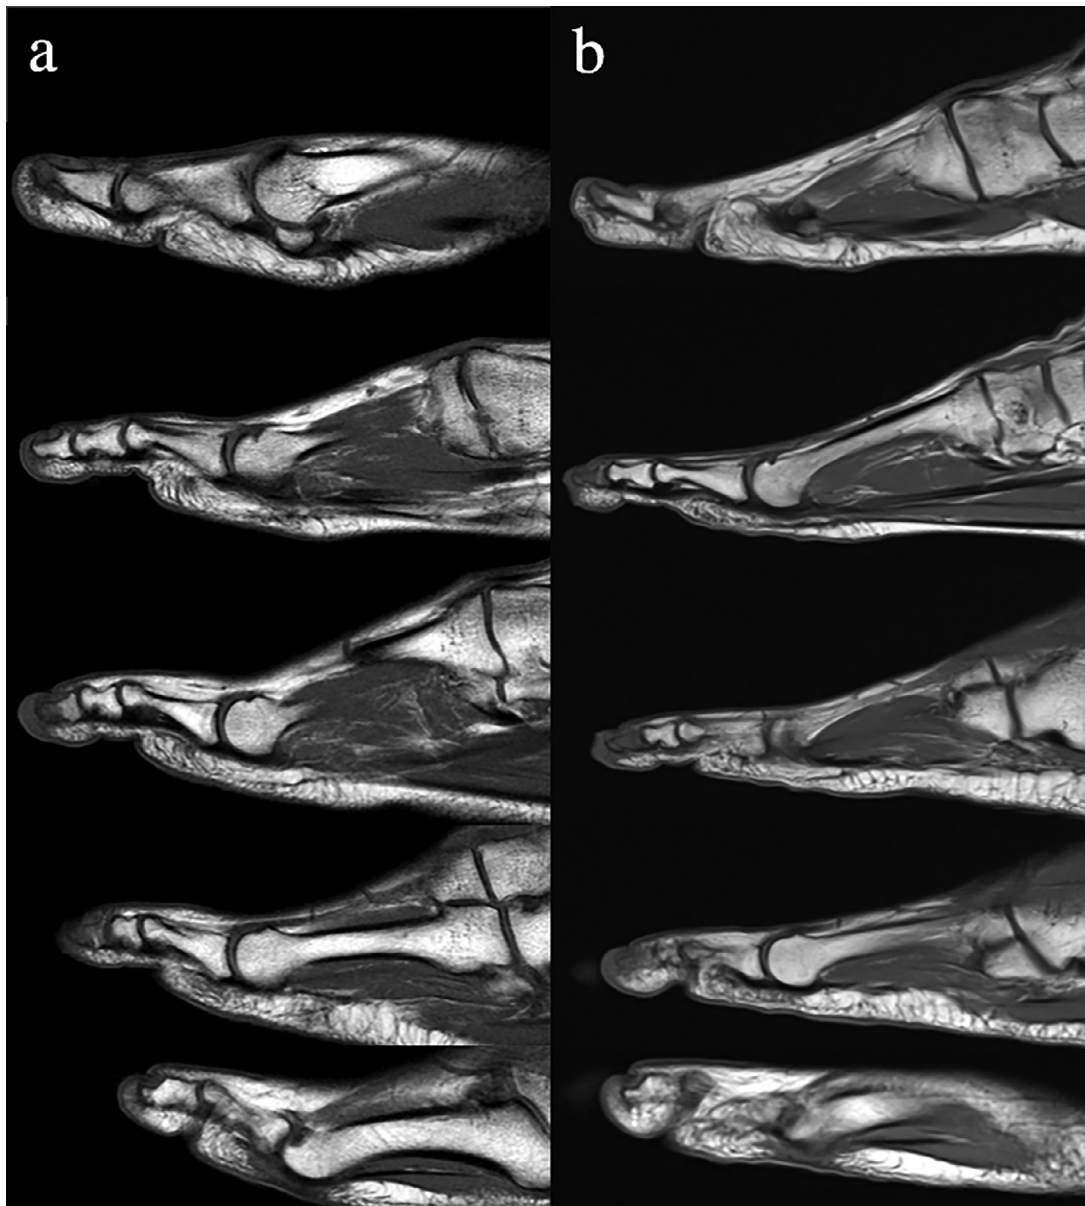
Initial (a) and 2.5-year follow-up (b) T1-weighted MRI images of the right foot demonstrate progressive distal-to-proximal hypointense signal abnormalities of the distal phalanges. Toes are arranged from first (top) to fifth (bottom).
